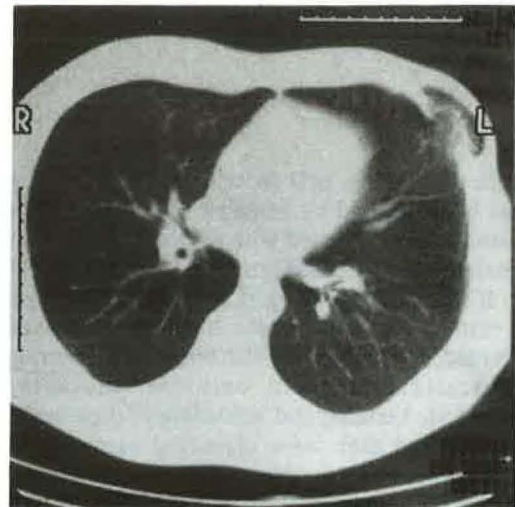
CT of the chest. A: expiration (CT level 104). B: inspiration (CT level 110). CT: computed tomography.
